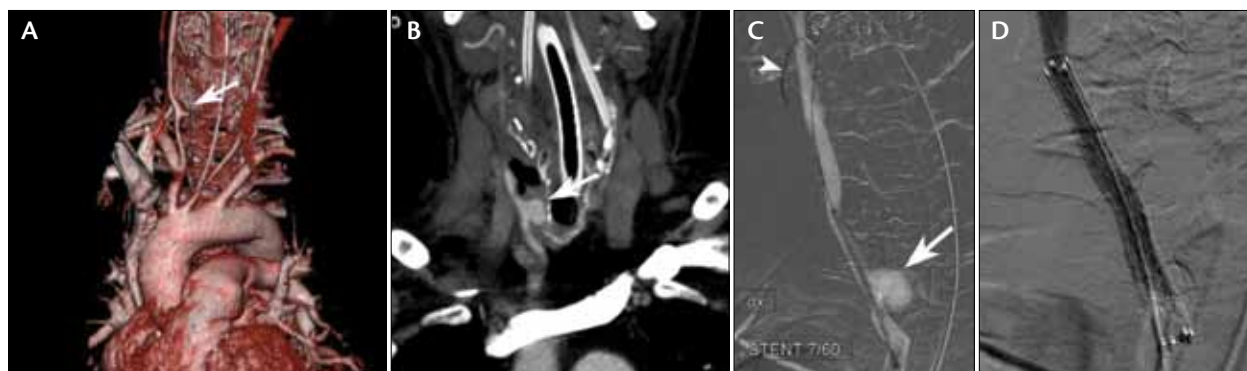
CT angiography. Volume-rendered image (A) and coronal MPR (B) showing a false aneurysm of the right common carotid artery (arrow). Roadmap image showing the false aneurysm (arrow) and the undeployed stent in place (C). Note the position of the tip of the stiff guidewire in the external carotid artery (arrowhead). Control angiography showing the deployed stent and full exclusion of the false aneurysm (D).
